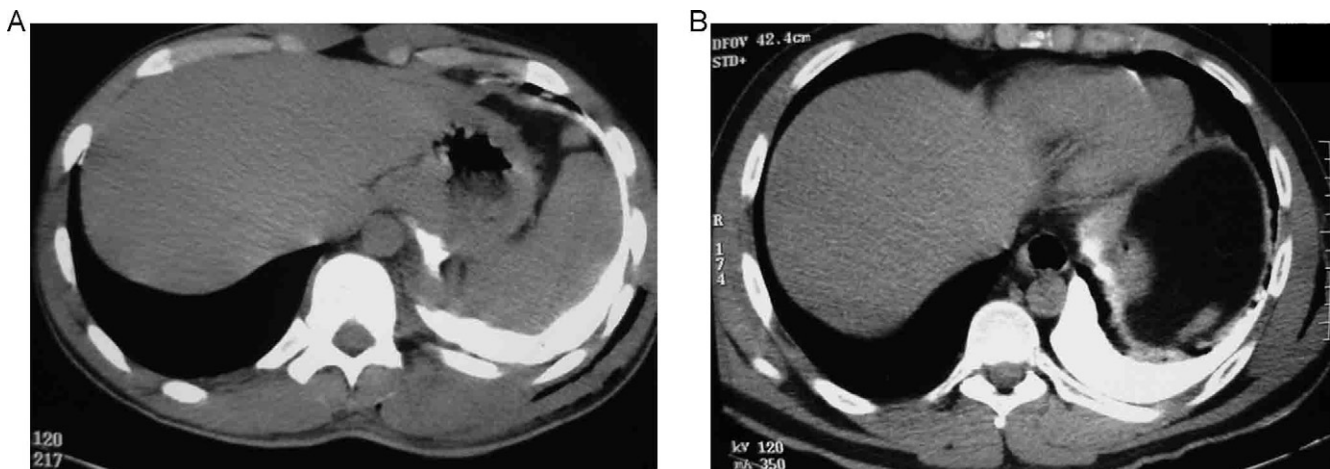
Intrapleural contrast CT-scan in the 2 false positive cases. (A) CT-scan showed minimal amount of contrast agent in the left subdiaphragmatic and splenorenal areas. (B) Extravasation of contrast agent in left subdiaphragmatic area and just upper stomach area were noted.
